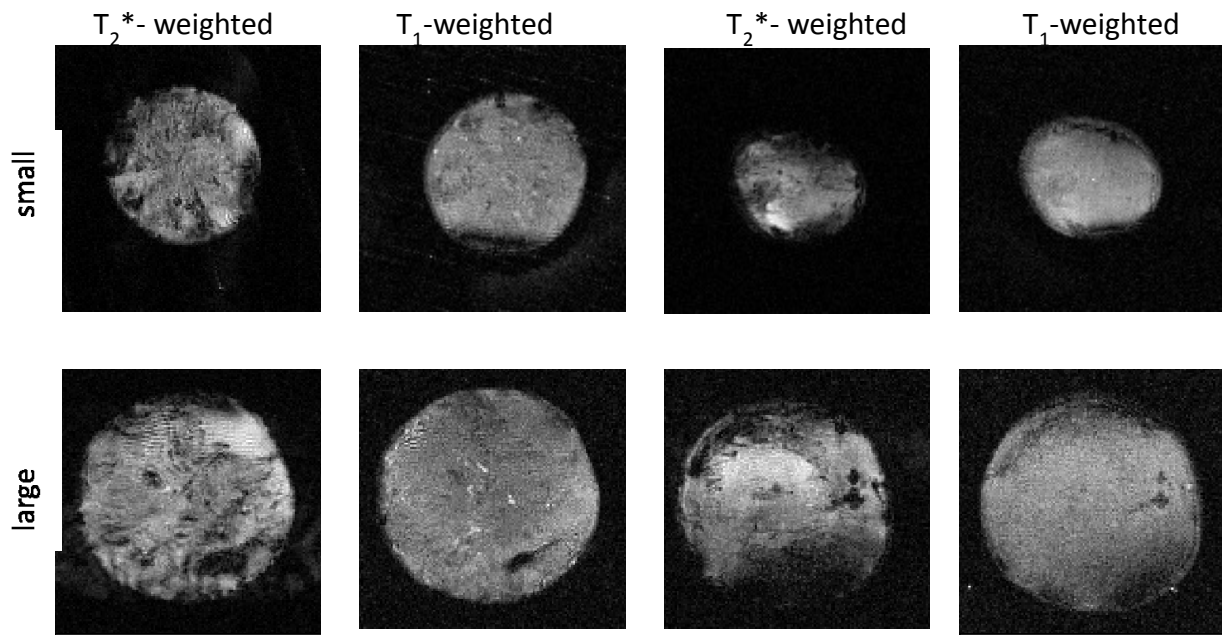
¹H MRI of Dunning prostate tumors.
